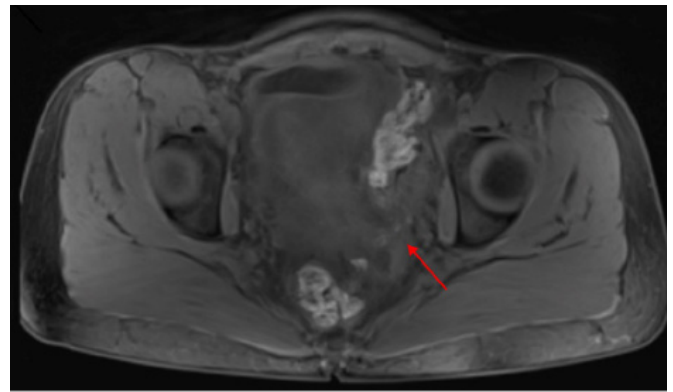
T1-Weighted MRI Pelvis Reveals Multiple Hyperintense Foci Suggestive of Peritoneal Seeding. Published with Permission
